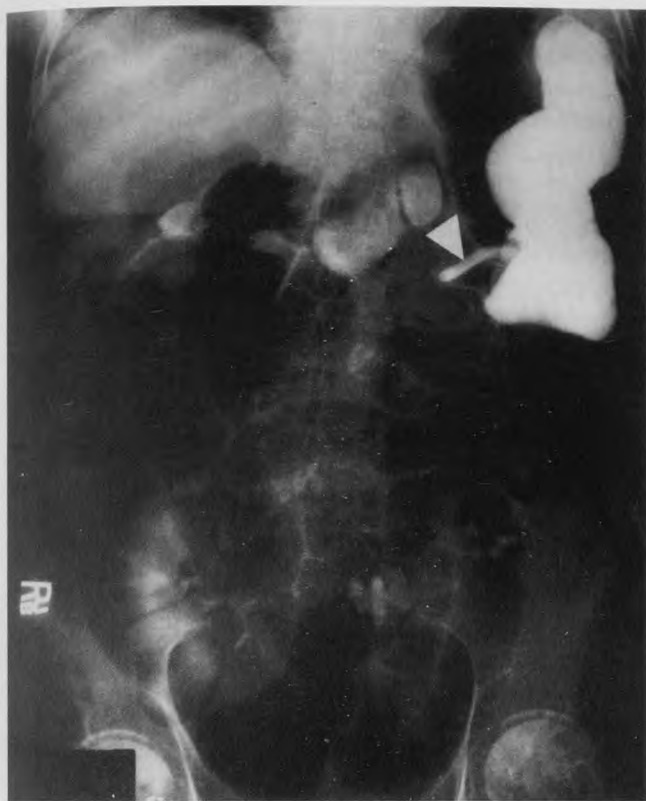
Radiographic study demonstrates filling of the colon rather than the stomach during instillation of Gastrografin. The PEG tube is indicated by the arrow.
